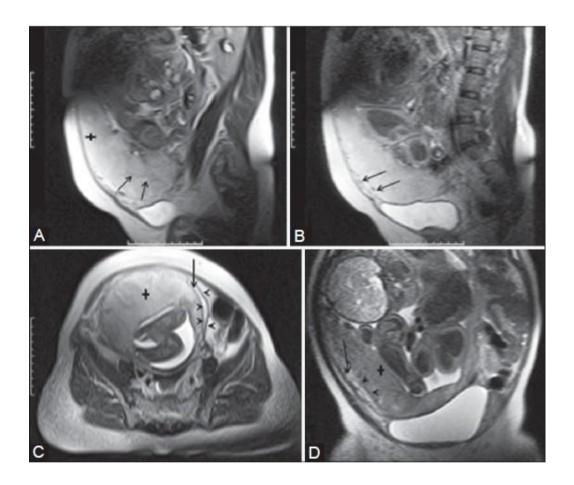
MRI appearance of normal placenta
